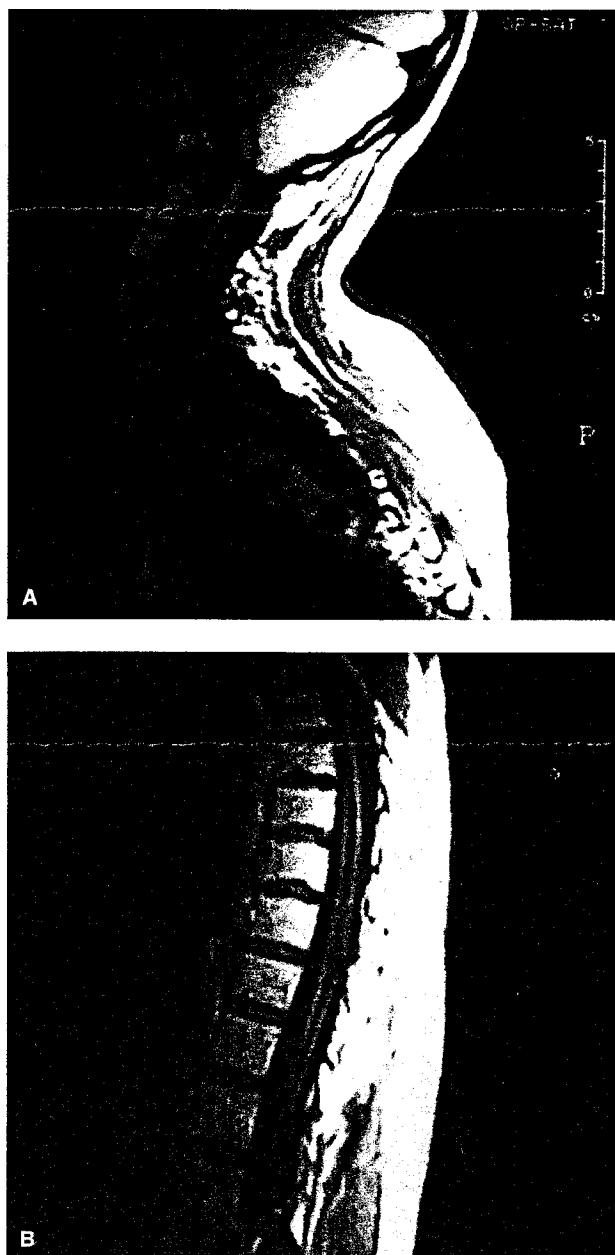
(A) Cervical spine (by magnetic resonance imaging): Chiari I anomaly, cord atrophy, and a collapsed syrinx; and (B) thoracic spine (by magnetic resonance imaging): an extensive syrinx along the thoracic spinal cord.
